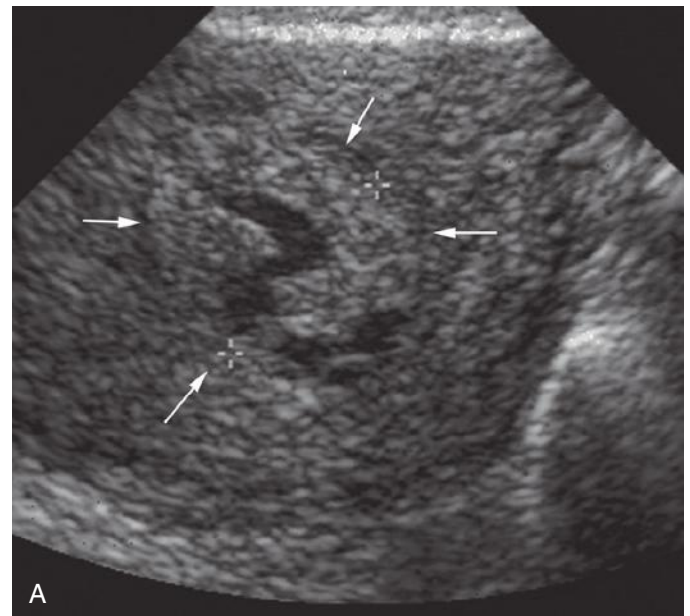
A, Sonogram from a patient with persistent bleeding following a first trimester therapeutic abortion. Tissue and fluid (arrows) representing retained products of conception (RPOC) are seen within the distended endometrial cavity (calipers). B, Doppler imaging of the same patient demonstrates markedly increased vascularity within the tissue consistent with RPOC.
